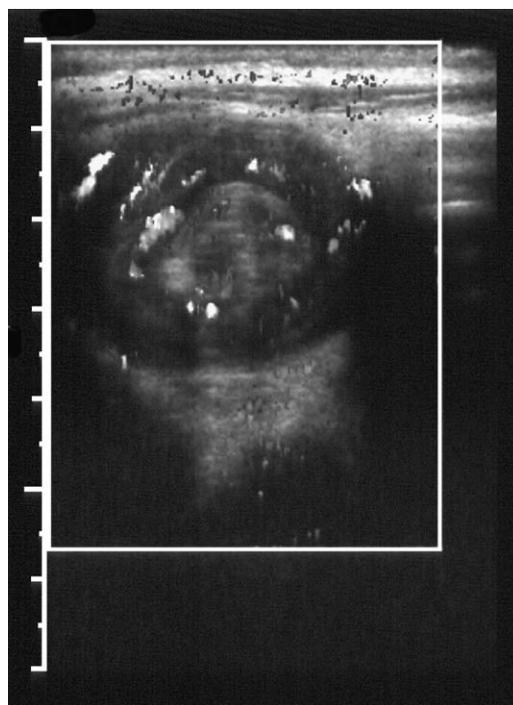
Use of Doppler ultrasound to evaluate intussusception. Doppler ultrasound shows blood flow within the intussusception, suggesting its reducibility.
